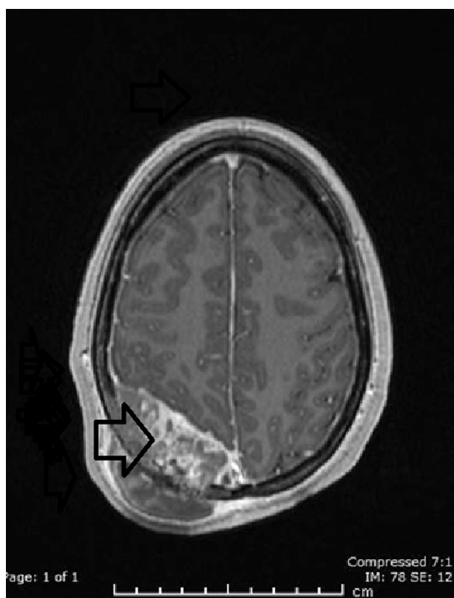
Axial post contrast MRI demonstrates the aggressive enhancing mass (arrow) involving the right parietal bone with both extra- and intracranial involvement.
